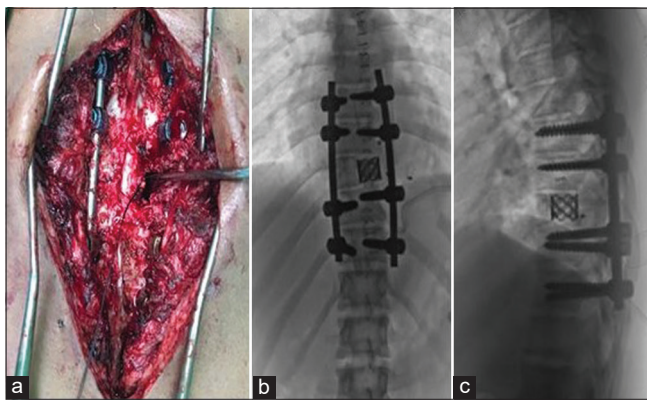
(a) Intraoperative picture showing cord decompression left side excision of lesion. (b and c) Postoperative thoracic spine X-ray AP view and lateral view showing posterior spinal decompression and instrumented fusion T7-T11 with anterior cage reconstruction of T9 vertebra.
